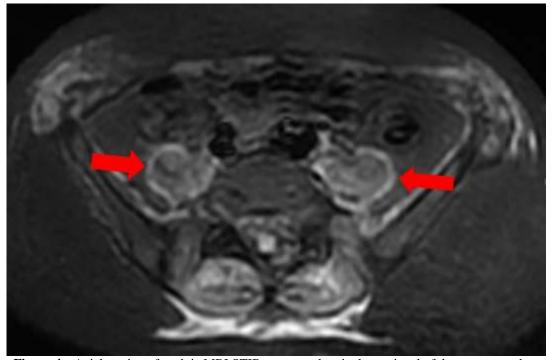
Axial section of apelvic MRI STIR sequenceshowing hypersignal of the psoas muscle.
